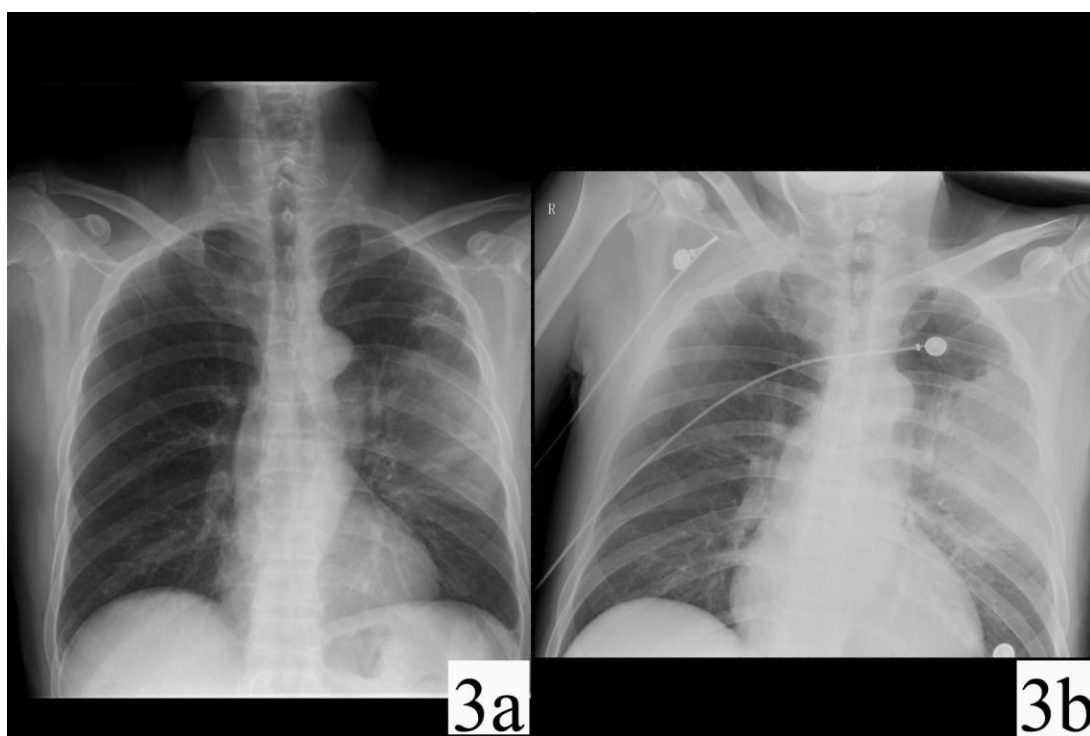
Images of the 3rd case: (a) Chest X-ray showed infiltration in the left lung and subpleural consolidation. (b) Chest X-ray revealed a large area of consolidation in the left lung
